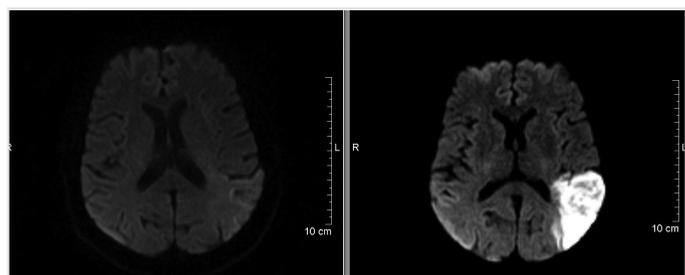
Left MCA infarct in cranial diffusion MRI (performed at the end of the second day)
